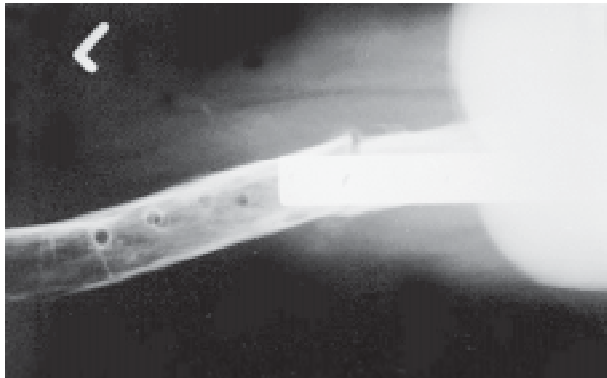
Lateral X-ray view of fracture with no dislocation at the lowest point of the osteosynthesis plate, due to sudden muscular contraction in a patient with type I osteogenesis imperfecta.
